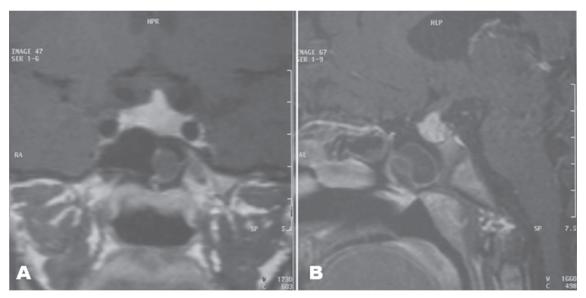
Pretreatment MRI of the pituitary gland. T_1 -weighted coronal (A) and midsagittal (B) images show an intrasellar, heterogeneously enhancing mass with suprasellar extension.
